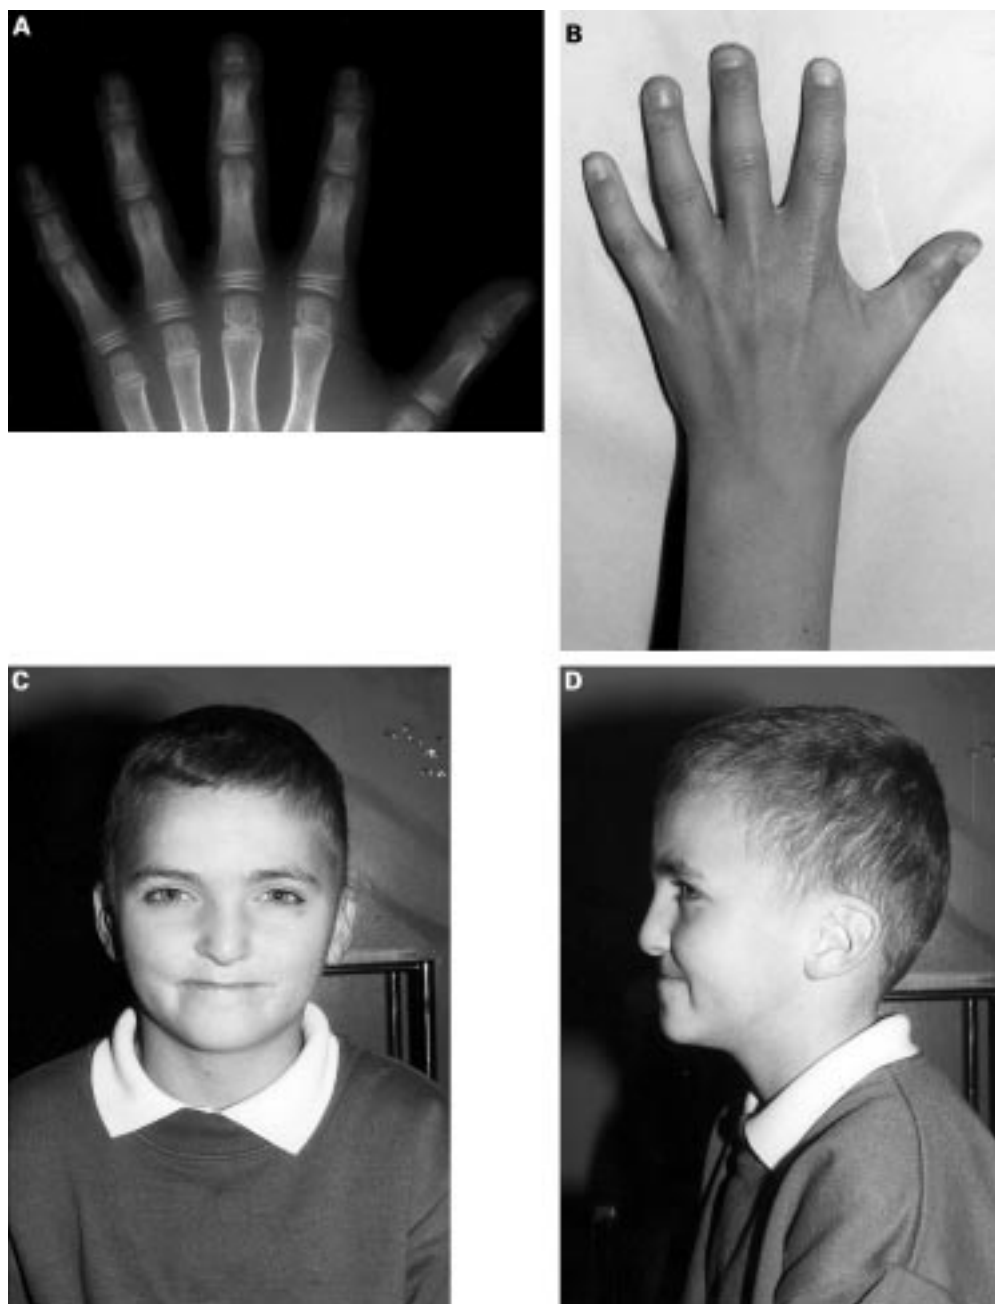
(A) Radiograph of left hand showing shortening of distal phalanx of middle finger. (B) Dorsum of left hand. (C) AP and (D) lateral views of our patient, aged 9, showing facial dysmorphism similar to that in Binder syndrome (see text for description).
